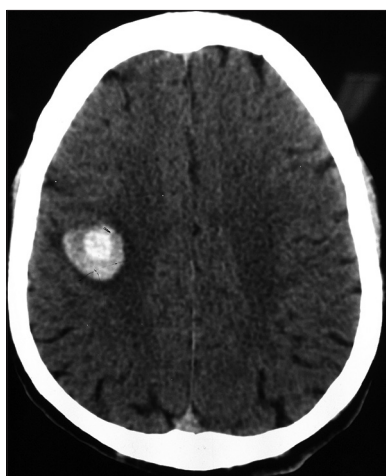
Computed tomography scan brain plain showing hyperdense, well-defined lesion in the right posterior frontal region
